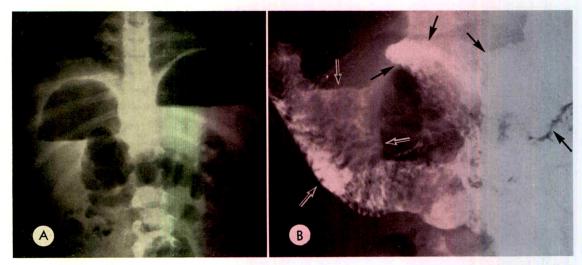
Case IX. (A) Erect roentgenogram of the abdomen in an asymptomatic 19 month old female who had had a side-to-side anastomosis for jejunal atresia 24 hours after birth. The fluid level in the left upper quadrant is within the gastric fundus. The fluid level in the right upper quadrant is within the distended blind pouch of the proximal segment of the jejunal anastomosis. (B) A gastrointestinal study reveals the stomach and duodenum in the left upper abdomen (black arrows). The markedly distended blind pouch (white arrows) occupies most of the right side of the abdomen. Note the fluid level (vertical arrow). Gas above this level also lies within the blind pouch.
